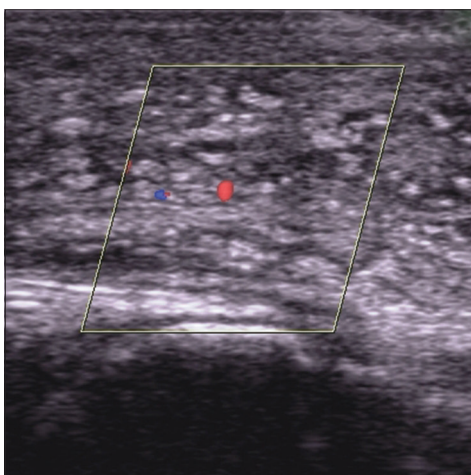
Sonogram of a 15 year old male with chronic subcutaneous oedema giving the 'cobble stone appearance' and dilated lymphatic channels
